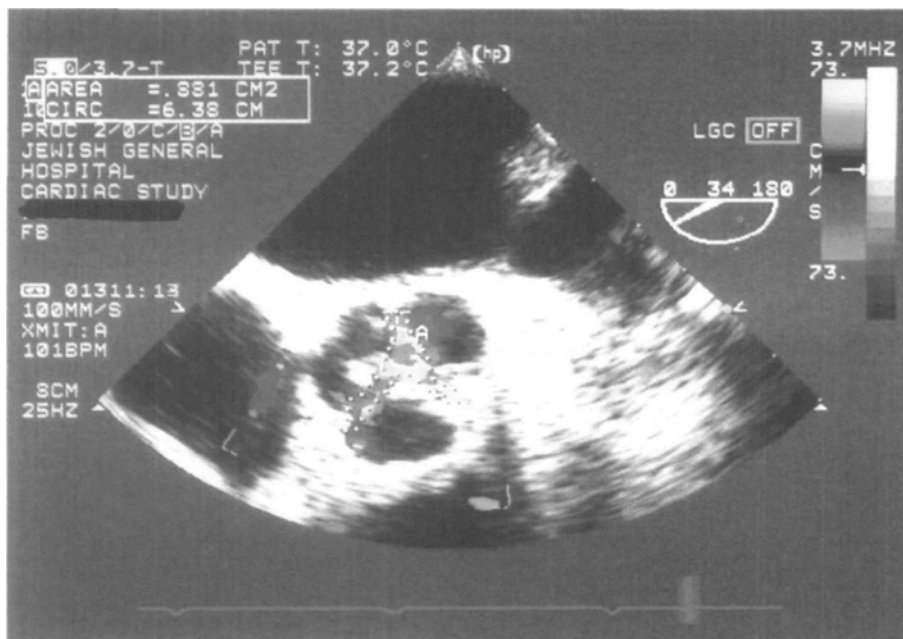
Aortic valve area measurement using colour Doppler guided planimetry. (Short axis view of the aortic valve during systole).
